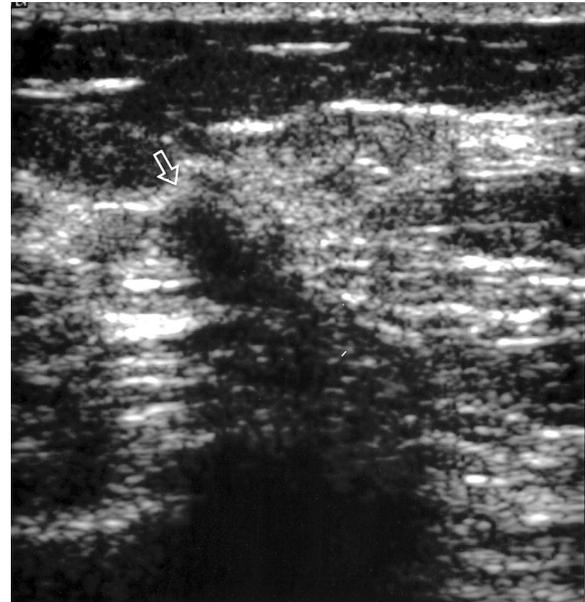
Six months follow-up ultrasonogram of the left breast revealing a reduced lesion size, from about 1.5 cm to 1.0 cm in diameter (arrow).
